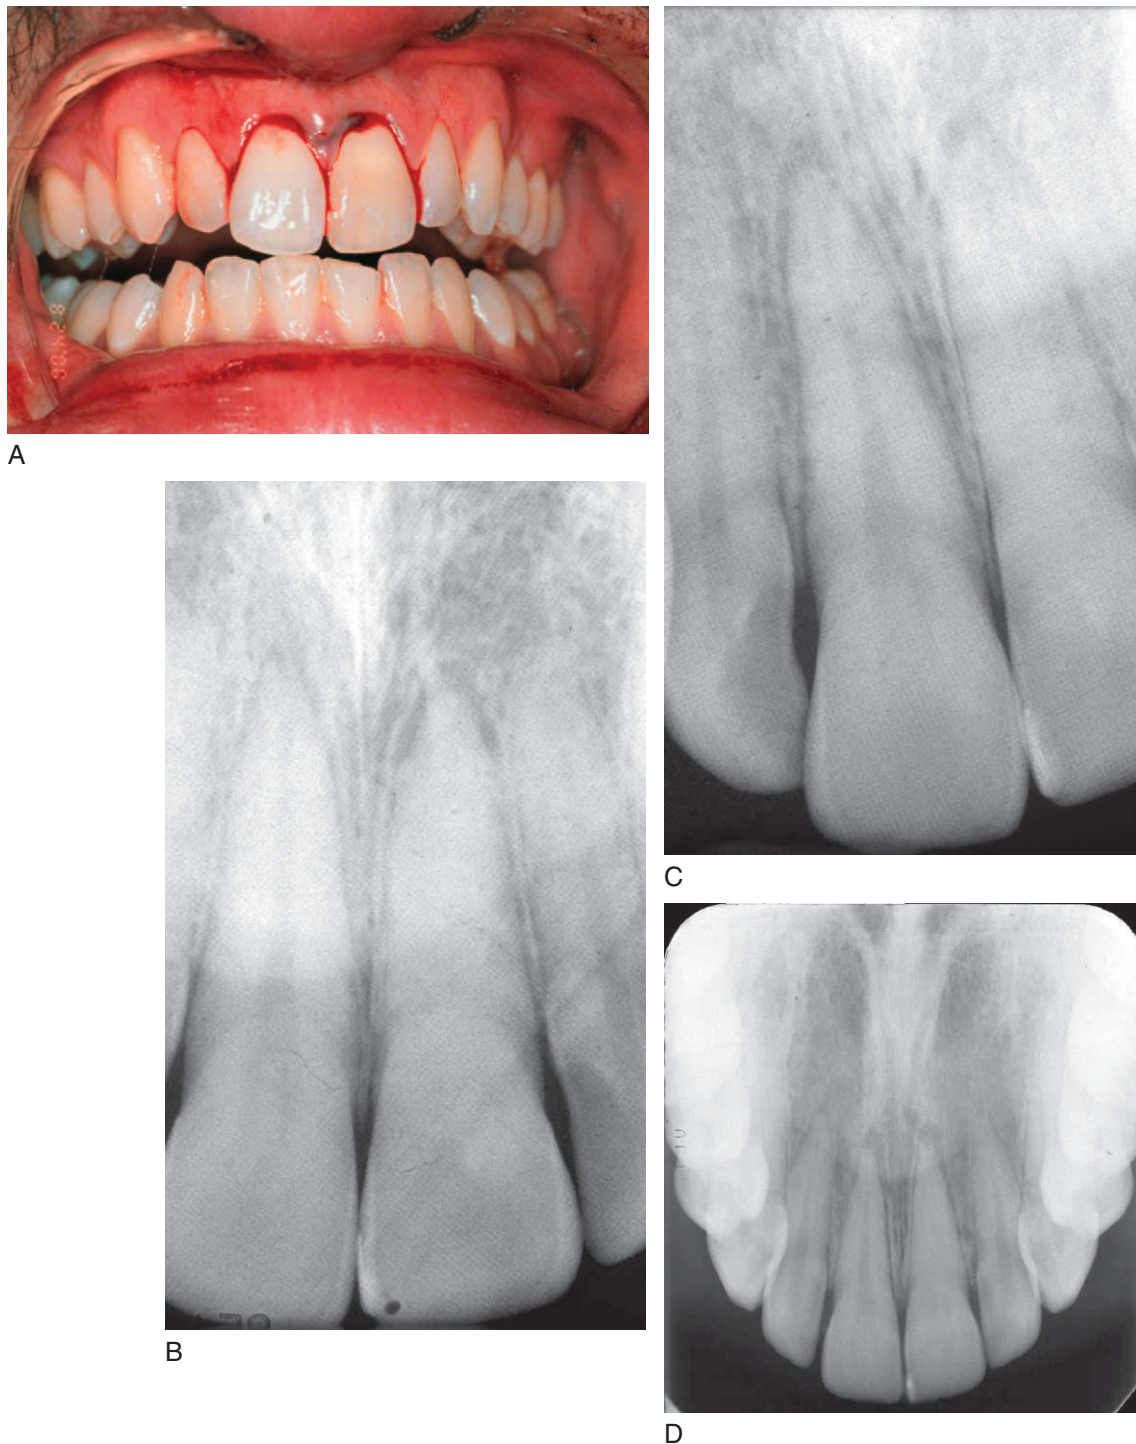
A, Luxated maxillary left central incisor. Note sulcular bleeding. B to D, Three different radiographic angulations of the same luxated tooth, showing that the apex has moved out of its original position.
